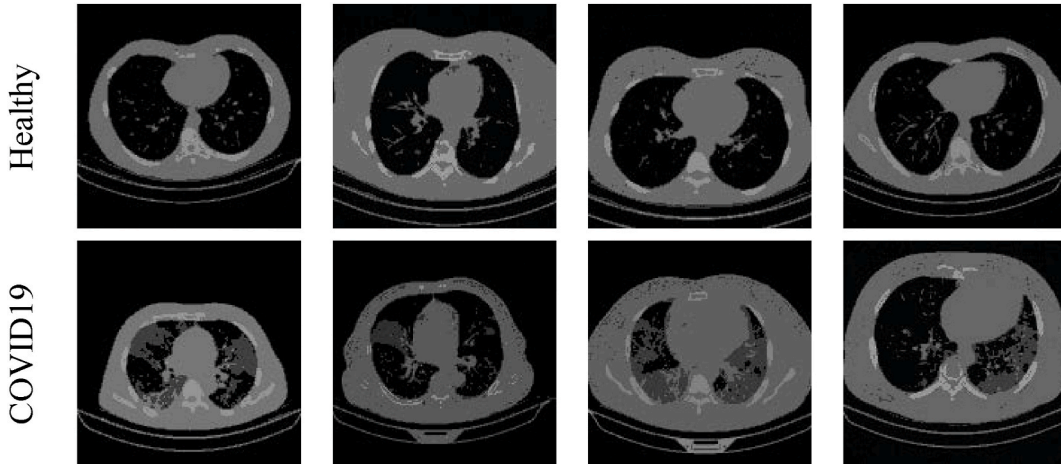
Preprocessed lung CT slices with the chosen approach.
